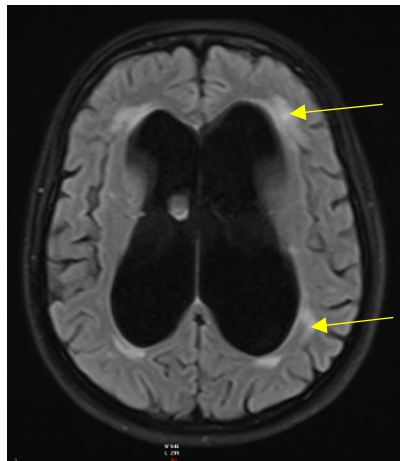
An MRI scan showing the periventricular white matter changes around the lateral ventricles, indicated by the yellow arrows.
